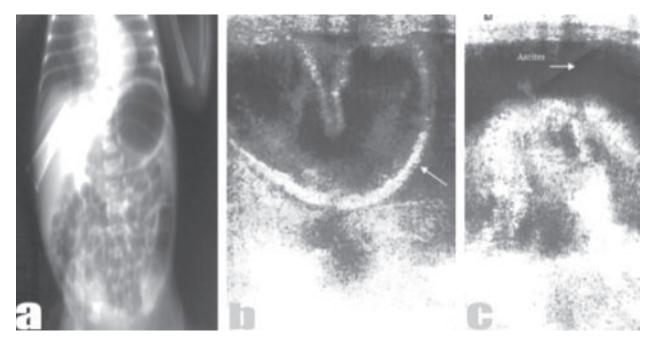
A case of late necrotizing interocolitis; a neonate ±30 weeks, with hypoxic ischemic encephalopathy, with formula feeding. (a) Plain X-ray showing gaseous distension. (b) Sonogram shows sever gaseous distension with bright echoes in the intestinal wall. (c) Free ascites between the anterior abdominal and intestinal wall, between intestinal loops.
